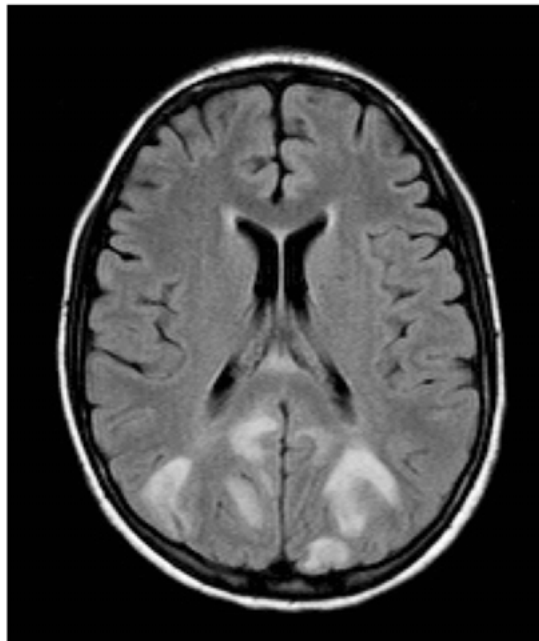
MRI T2 weighted image showing vasogenic edema in the parieto-occipital region. Used with permission from Johan Wikström.
